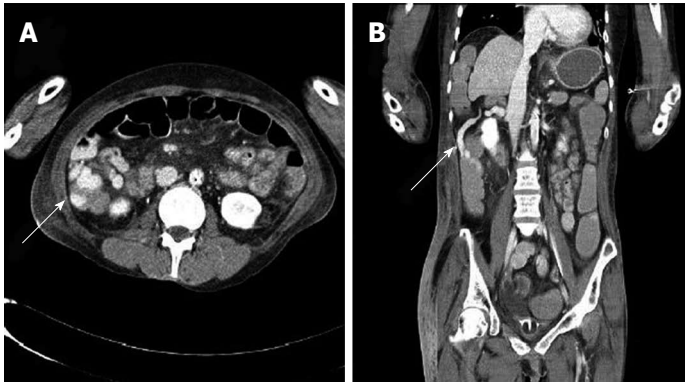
Abdominal computed tomography. A: Portal phase axial view with white arrow showing the varix surrounding and protruding inside the ascending colon formed by portacaval shunt; B: Coronal view with white arrow showing the colon varix.
